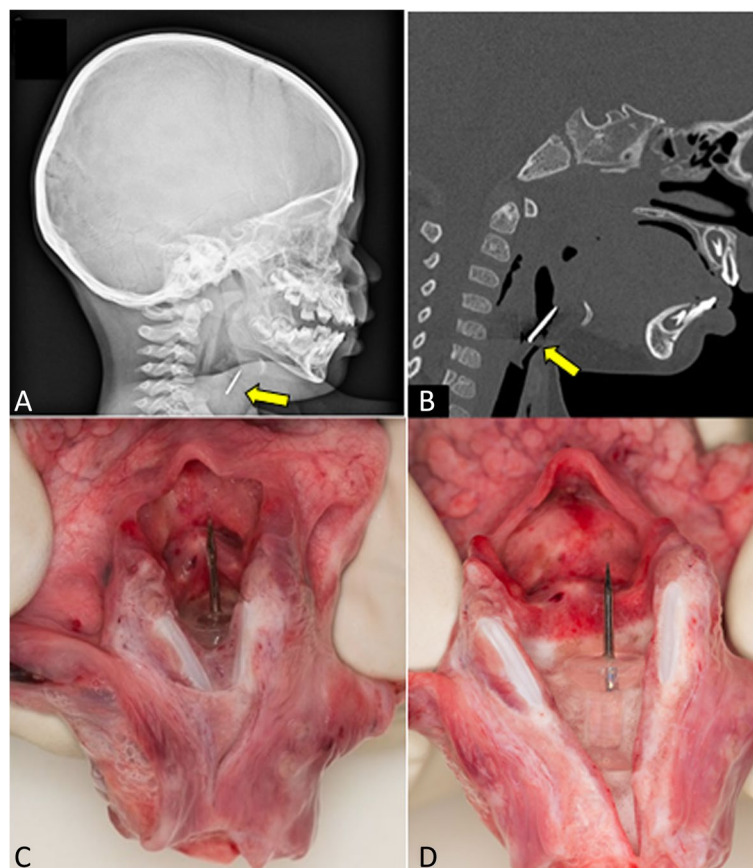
Postmortem diagnosis of push pin aspiration in a child. A Postmortem lateral head x-ray demonstrating a hyperdense, linear, pointed foreign body in the region of the larynx (identified with yellow arrow). B Postmortem CT (sagittal skull and c-spine reformat) demonstrating the same foreign body in larynx (identified with yellow arrow). C and D Sequential autopsy dissection photographs of the larynx, demonstrating the aspirated push pin made of clear plastic occluding the airway at the level of the vocal cords
